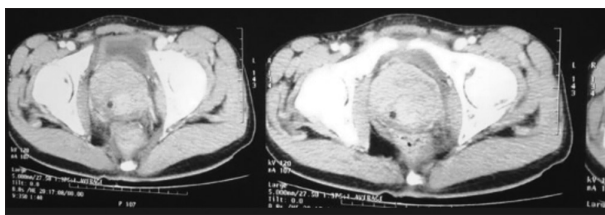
Computed tomography urography show prostate gland replaced by a large mass, mostly rhabdomyosarcoma
